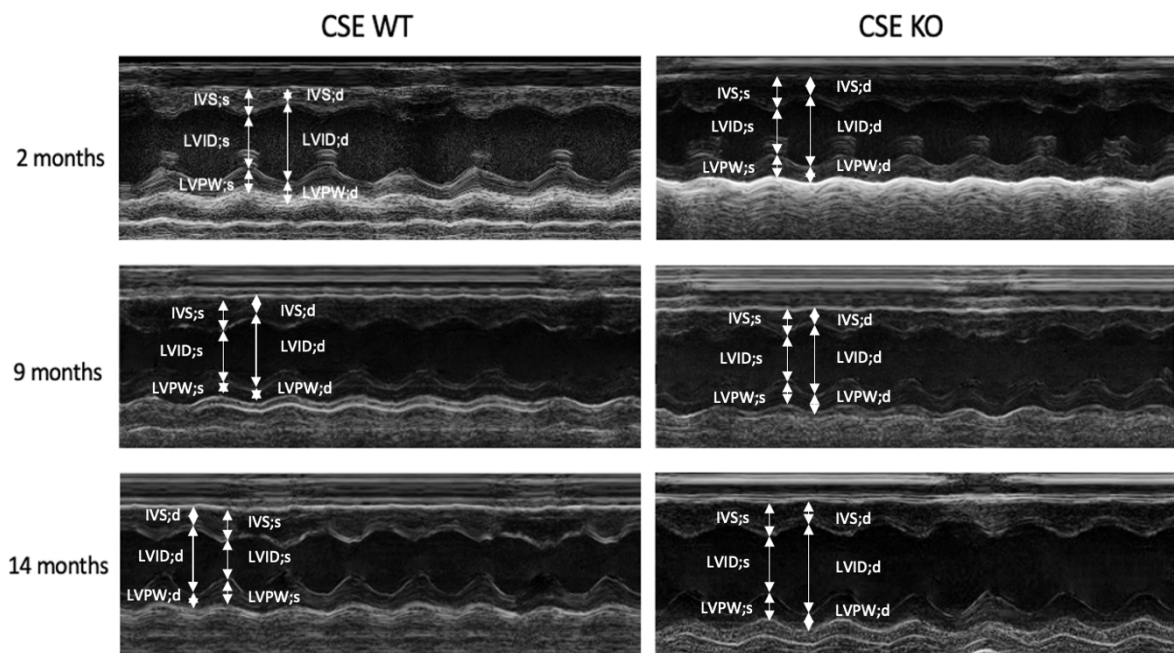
Representative M-mode images of the heart in parasternal long axis view showing the changes in wall motions and thickness during cardiac cycles.
